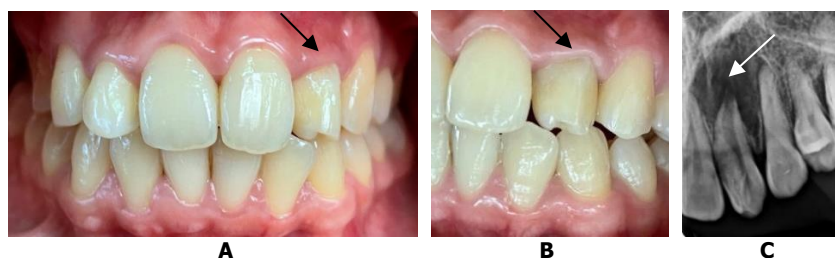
A,B. Initial clinical photo; C. Initial radiographic photo
